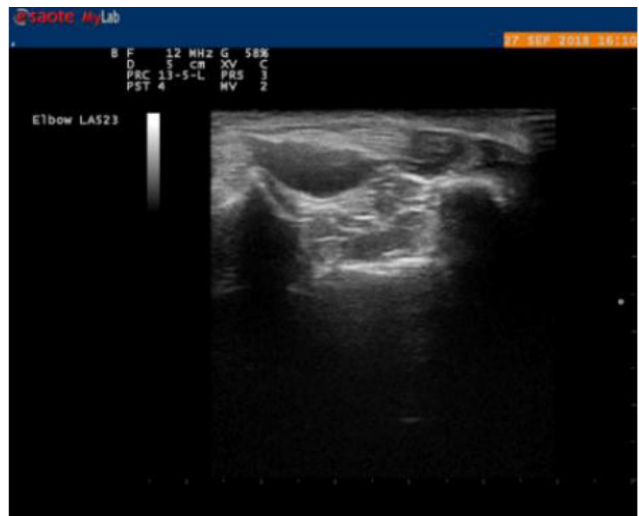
Ultrasound of right elbow.
